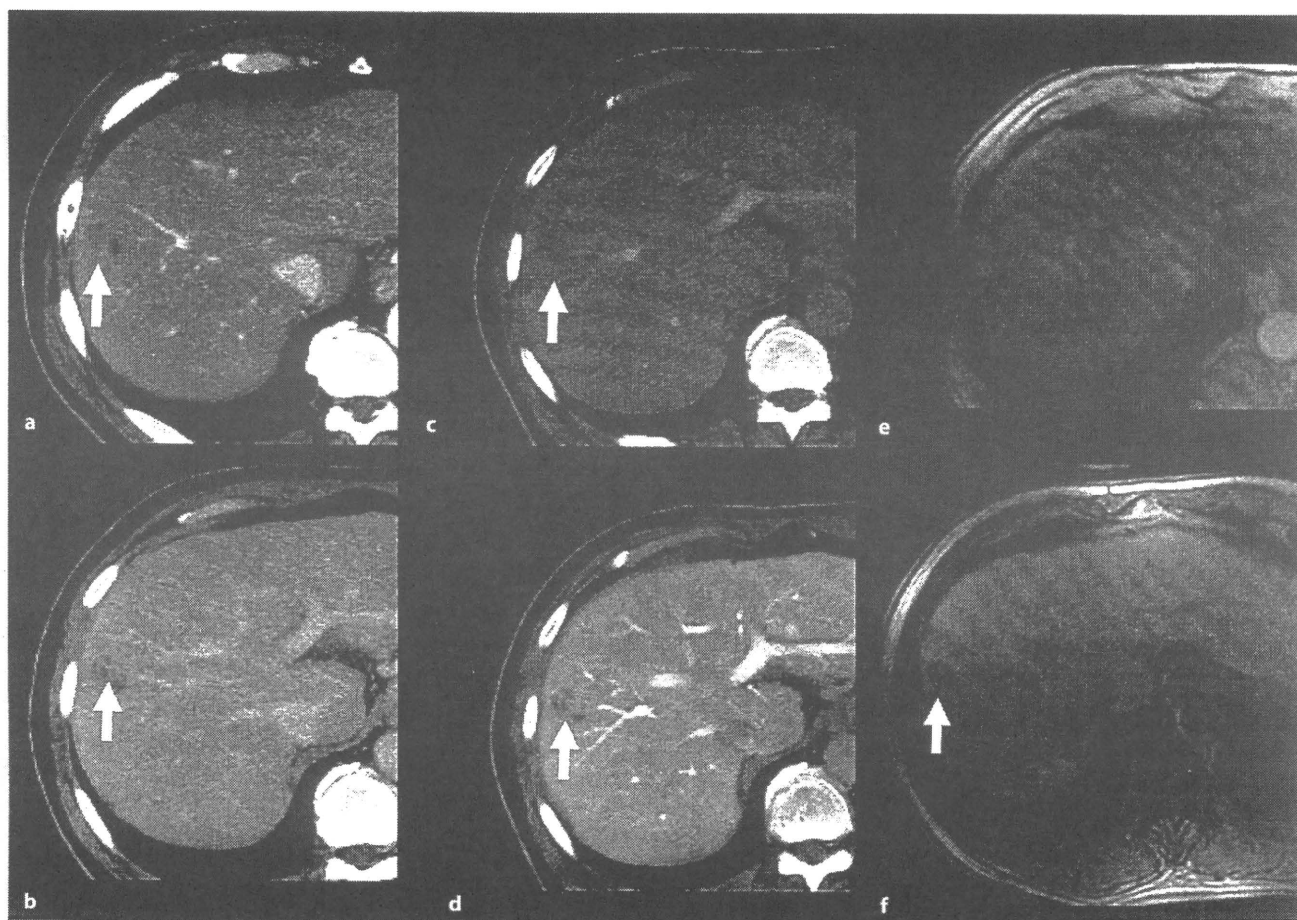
A representative case of hypovascular early HCC in a 75-year-old male. There is a hypovascular nodule with a diameter of 1.5 cm in segment 8 during the arterial phase in the dynamic CT scan (a) which becomes a low-density area during the equilibrium phase (b). CTHA also revealed a hypovascular region (c).
